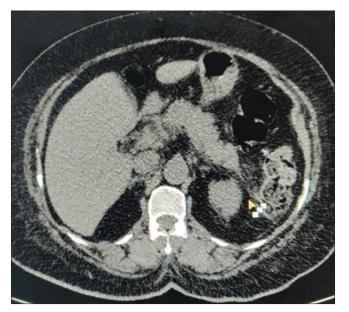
Non contrast CT at the level of pancreas, shows diffusely bulky pancreatic body and tail region with mild peripancreatic fat stranding (Yellow arrow head)
